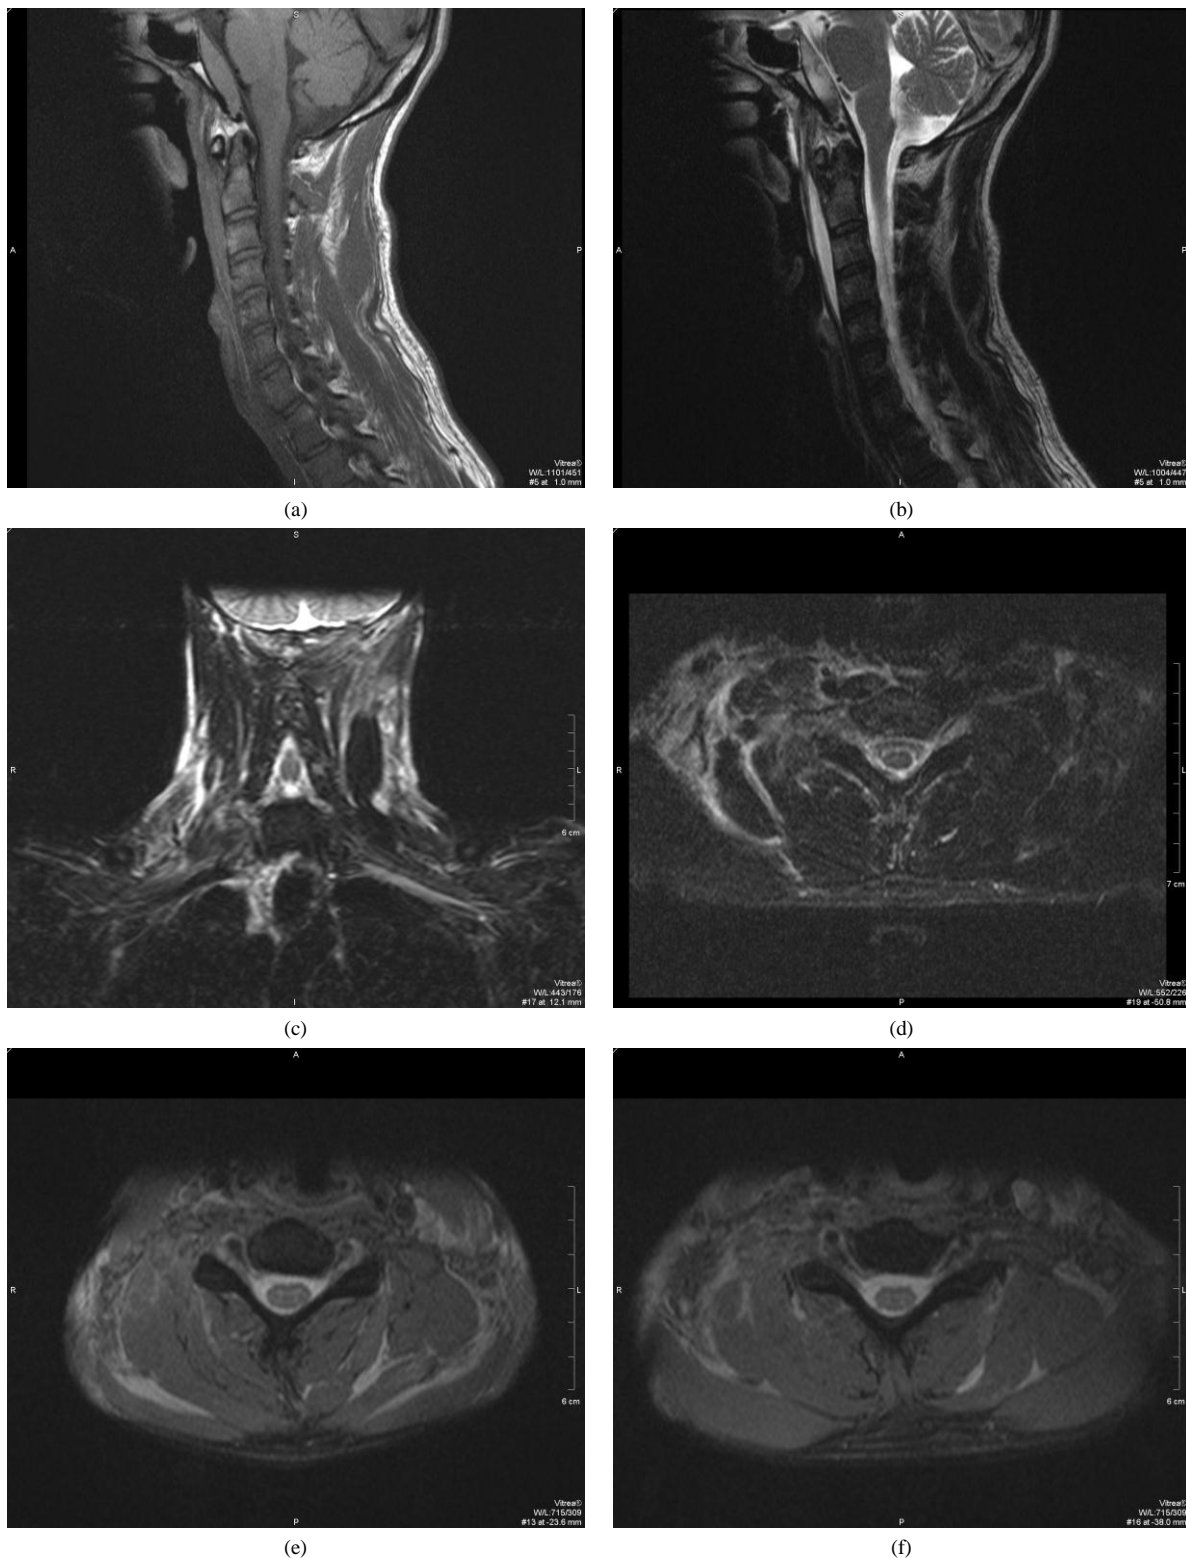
Sagittal MRI image of the cervical spine in (a) T1-weighted and (b) T2-weighted sequences. The images reveal a T1 slightly hyperintense and T2 hyperintense lesion just posterior to the clivus (white arrows), suggestive of a retroclival epidural hematoma. The sagittal MRI images also show a T1 slightly hyperintense and T2 hyperintense hematoma in the retropharyngeal space (white arrowheads). STIR images of the neck in coronal (c) and axial (d) views show T2 hyperintense signal over the muscles and soft tissue in right lower neck (white arrows), which could be due to traction injury. T2 hyperintense signal change is also seen in left suboccipital region (white arrowheads), likely related to the recent trauma. No pseudomeningocele is found in T2-weighted axial MRI images of the cervical spine at C6 (e) and C7 (f) levels to suggest nerve root avulsion.
